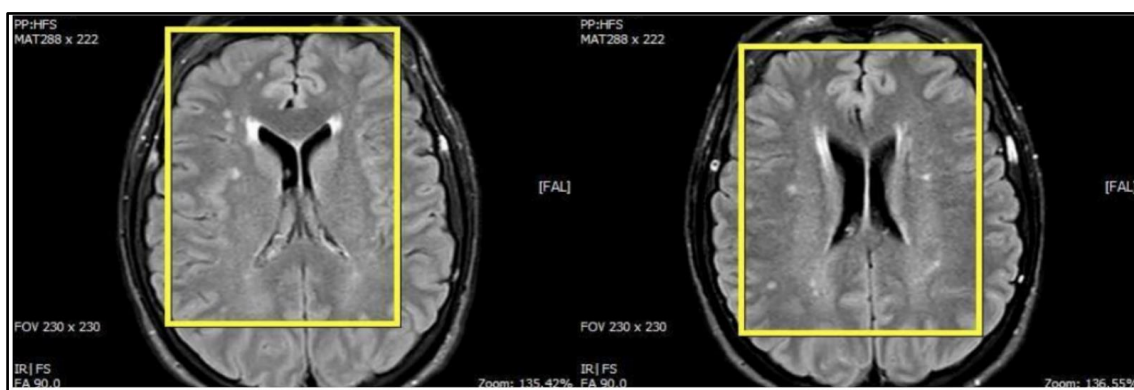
Axial FLAIR MRI sequences of the brain showing multiple hyperintense white matter lesions, which appear more numerous or prominent in the follow-up scan.
